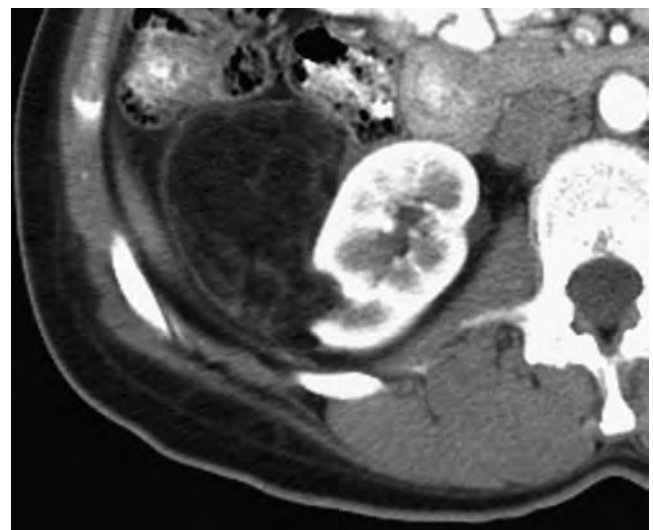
Computed tomography scan of angiomyolipoma with parenchymal indentation. (Copyright 2009, S. F. Matin.)
